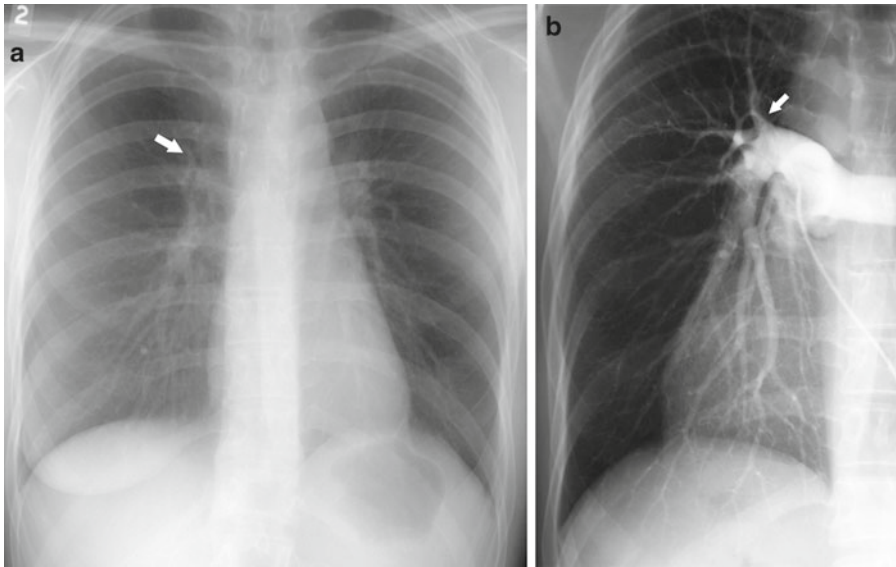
Radiation arteritis. (a) PA radiograph shows attenuation of the right upper lobe pulmonary artery (arrow) with a paucity of vessels in the periphery.
